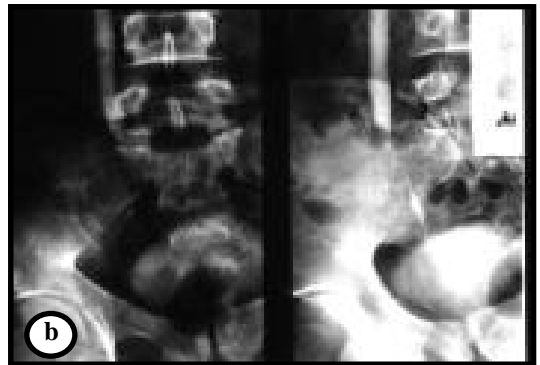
Plain film showing a) 15 minutes post-contrast image of bilateral calcified hydronephrosis with mild loss of renal cortex in the left kidney and b) post-contrast one hour delayed image of both ureters with hydroureter in the right side up to the inferior margin of right transverse process of lumbar segment of the vertebral column number 5 (L5).
